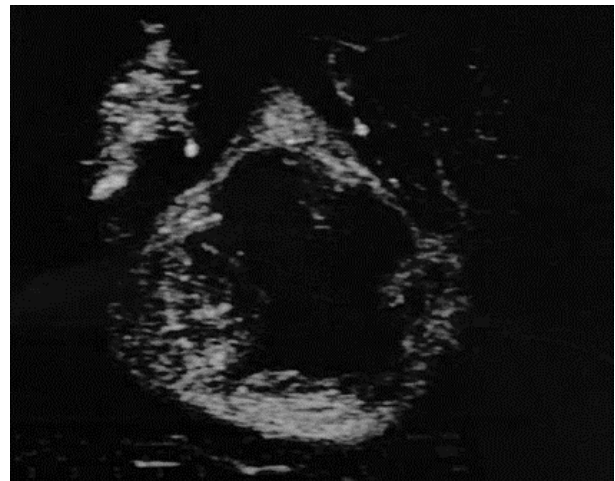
Intra-operative ultrasonography neuro-navigation showing the exact localization of deep motor cortex cavernoma.
